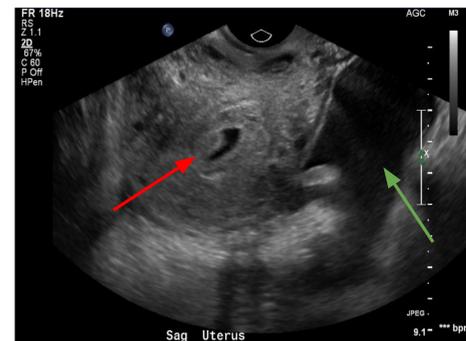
Ultrasound showing intrauterine gestational sac (red arrow) and large amount of free fluid (green arrow)
